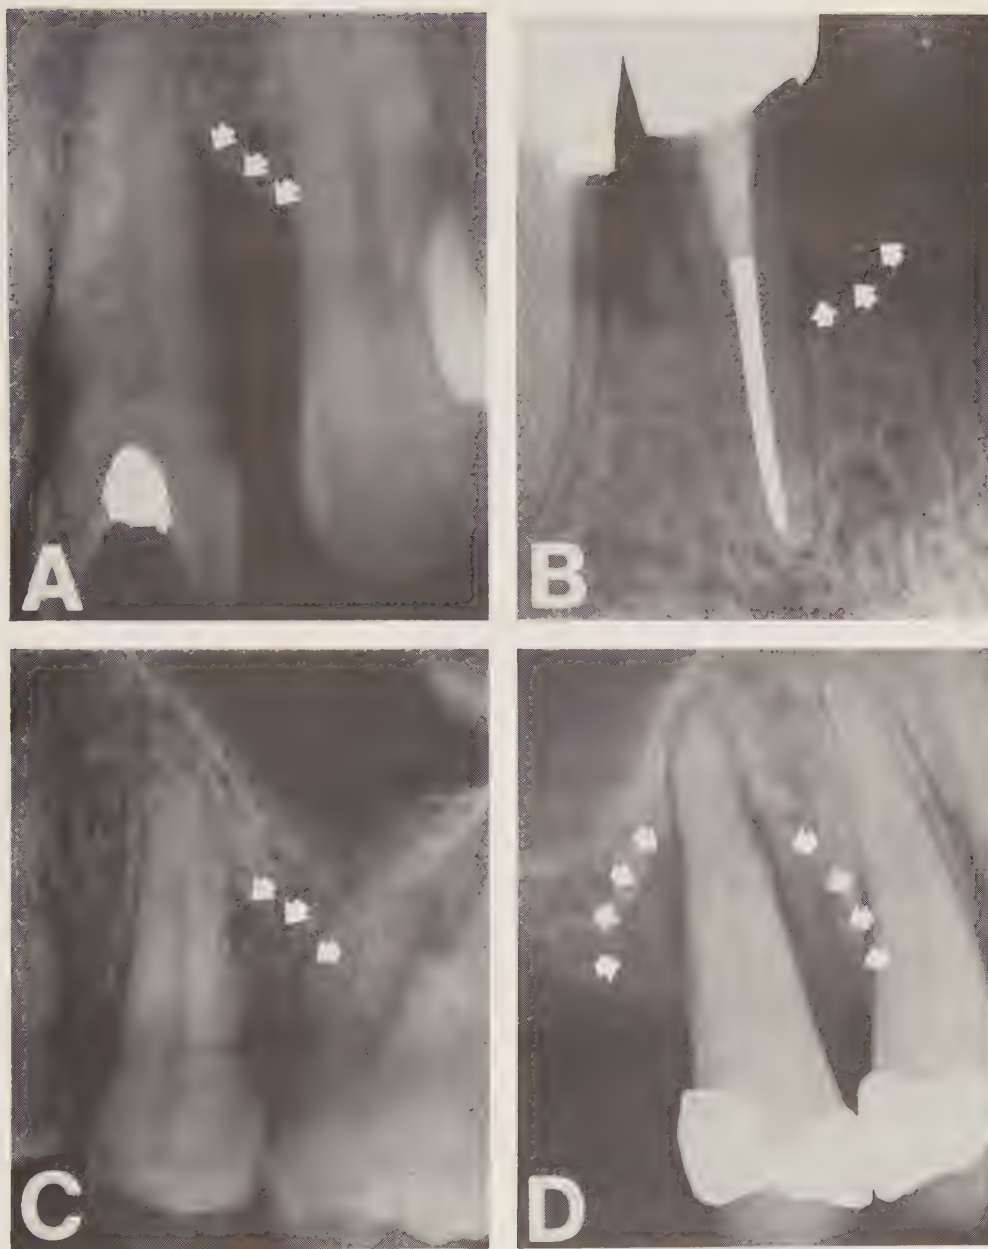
Radiographs of a selection of defects of different depths prior to surgery.
